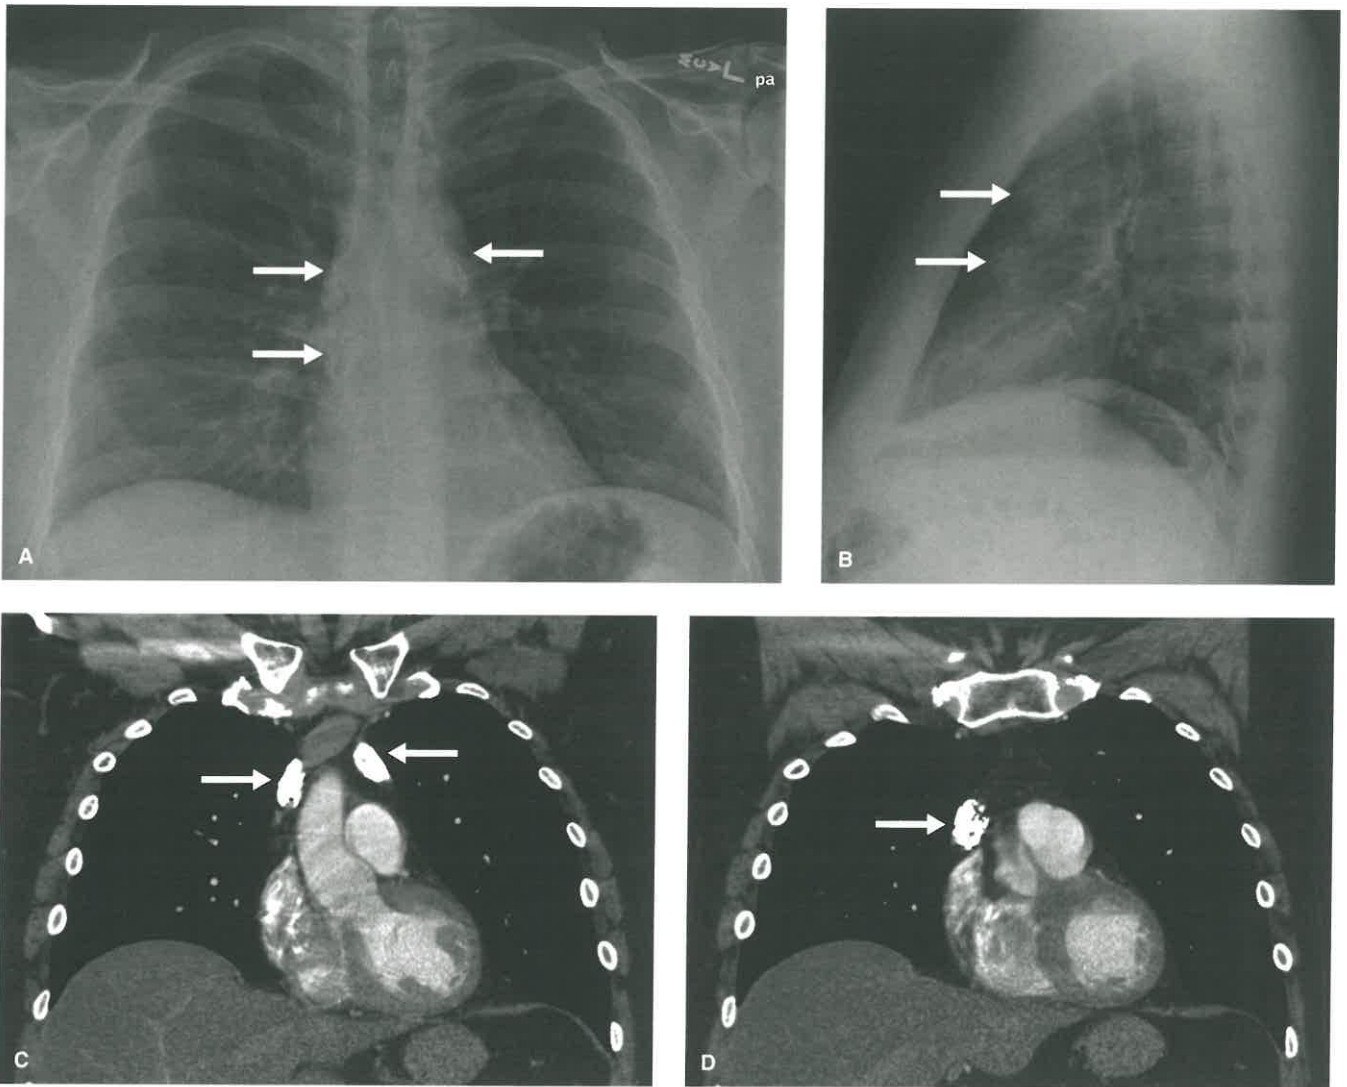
Treated Hodgkin Lymphoma With Residual Calcified Nodes. A, B: Chest radiographs in frontal (A) and lateral (B) projections demonstrate coarse anterior and superior mediastinal calcification (arrows). C, D: Contrast-enhanced coronal CT scans through the anterior mediastinum (C, D) show multiple calcified nodes (arrows) reflecting treated tumor.
